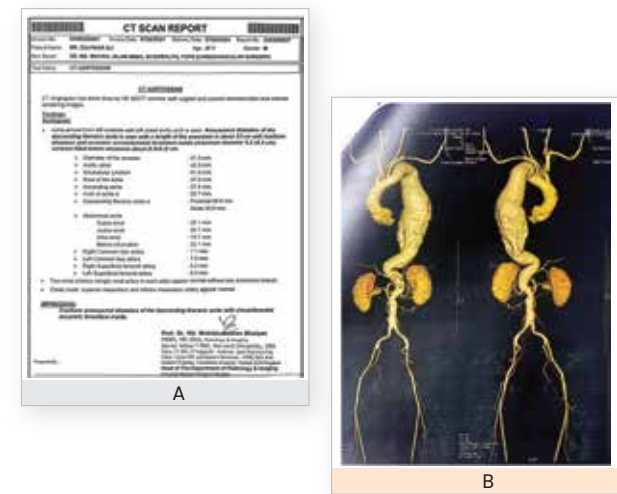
A) & B) CT angiogram of the patient
